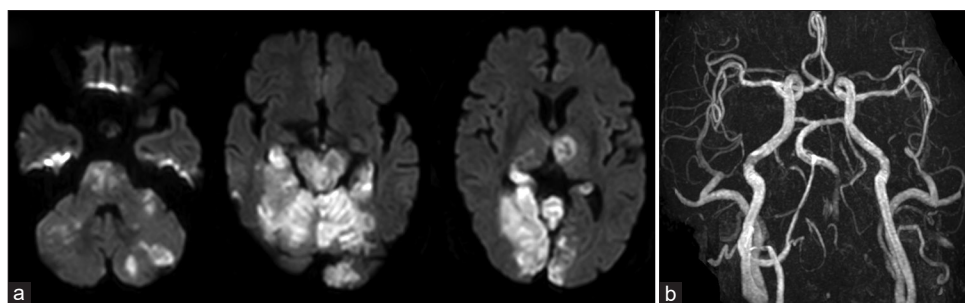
Magnetic resonance imaging findings 13 h after the onset of altered consciousness disturbance: (a) diffusion-weighted imaging shows hyperintense areas in the midbrain, pons, bilateral cerebellum, bilateral occipital lobes, and left thalamus. (b) Magnetic resonance angiography shows patency of the right vertebral and basilar arteries and occlusion of the left vertebral artery.
